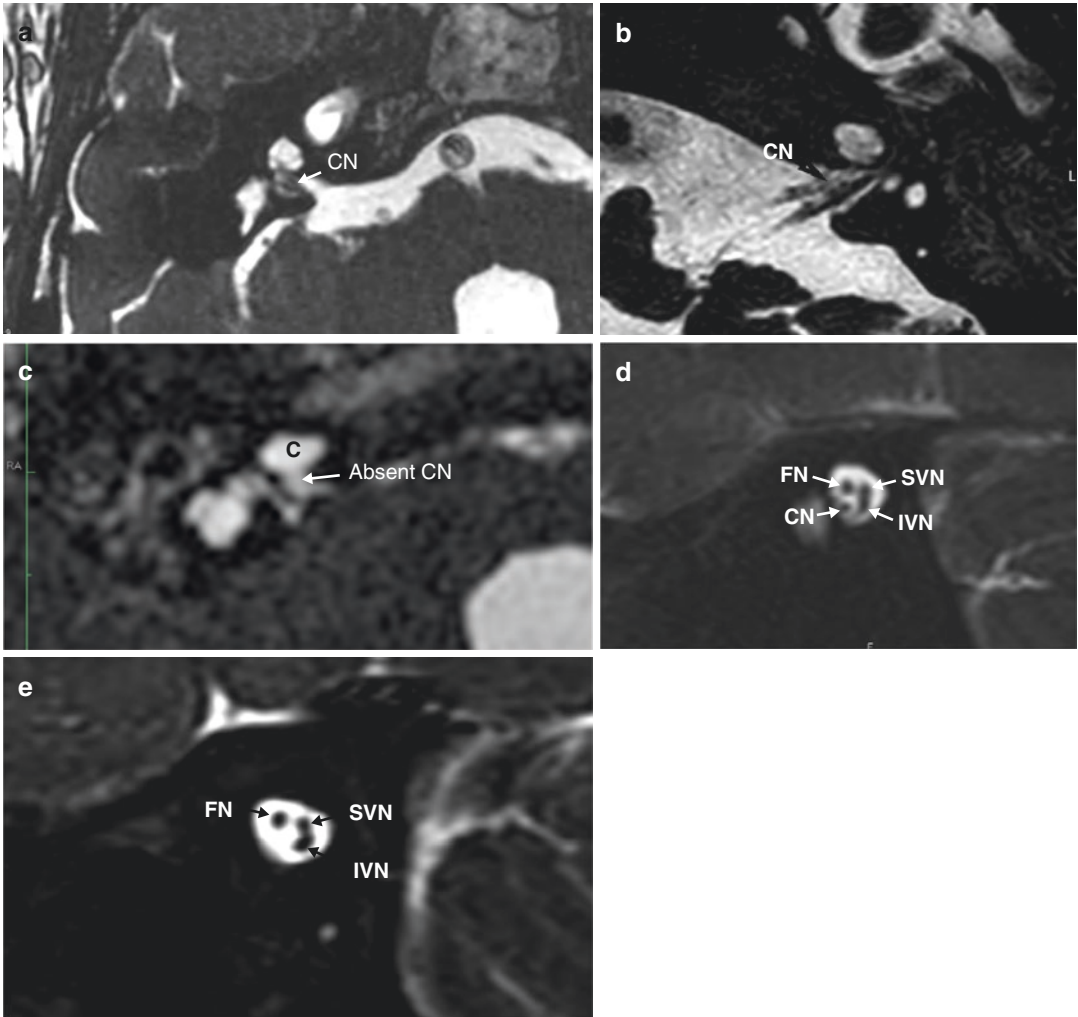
Magnetic resonance imaging of cochlear nerve (CN) in IP-I. CN can be normal (a), hypoplastic (b), or aplastic (c). Parasagittal section perpendicular to the IAC
